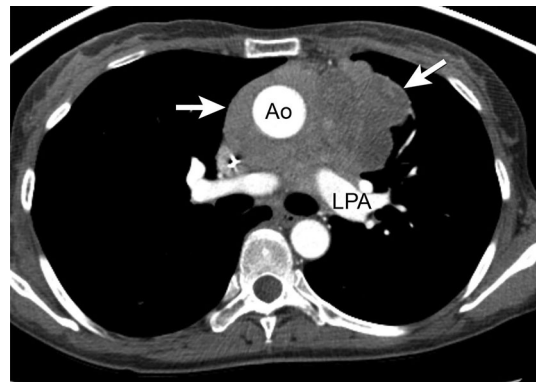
T4 tumor. Contrast-enhanced axial CT of the chest shows a large prevascular mediastinal mass (*arrows*) encircling the ascending aorta (Ao) and left pulmonary artery (LPA). At surgery, this thymoma involved the mediastinal pleura, lung parenchyma, pericardium, aorta, and left pulmonary artery, consistent with a T4 tumor.
